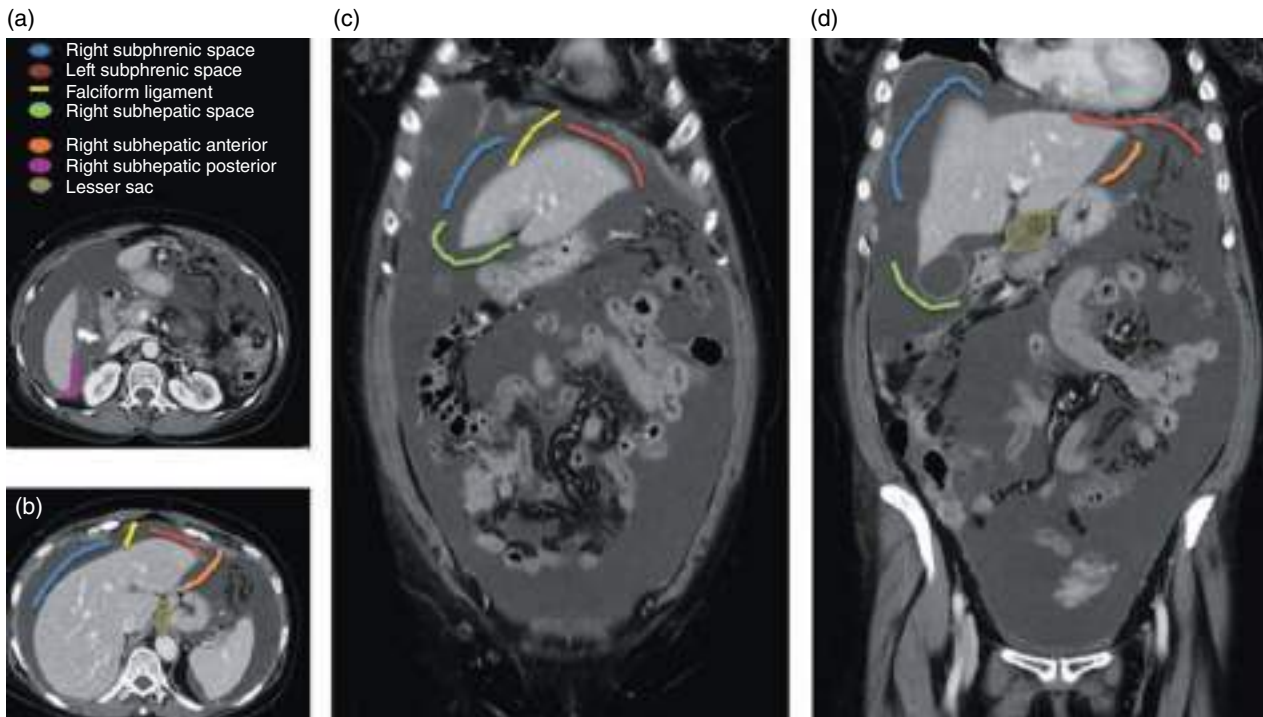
Supramesocolic compartments in patient with carcinomatous ascites due to ovarian tumor. (a, b) Axial contrast-enhanced CT image (portal venous phase). (c, d) Coronal contrast-enhanced MPR CT image (portal venous phase).
